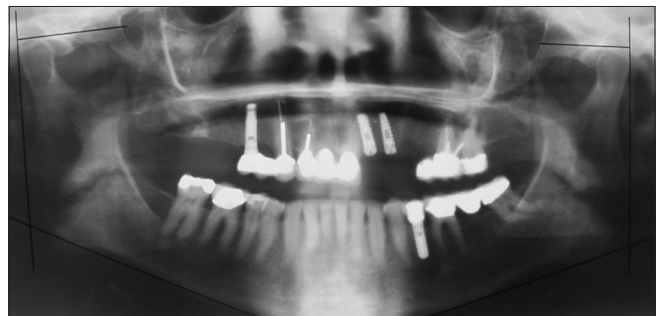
Radiograph with tracings for Case 43 (female). The lines as shown in Figure 2 have been drawn and measured. With this information the asymmetry index, it was calculated as -3.26
